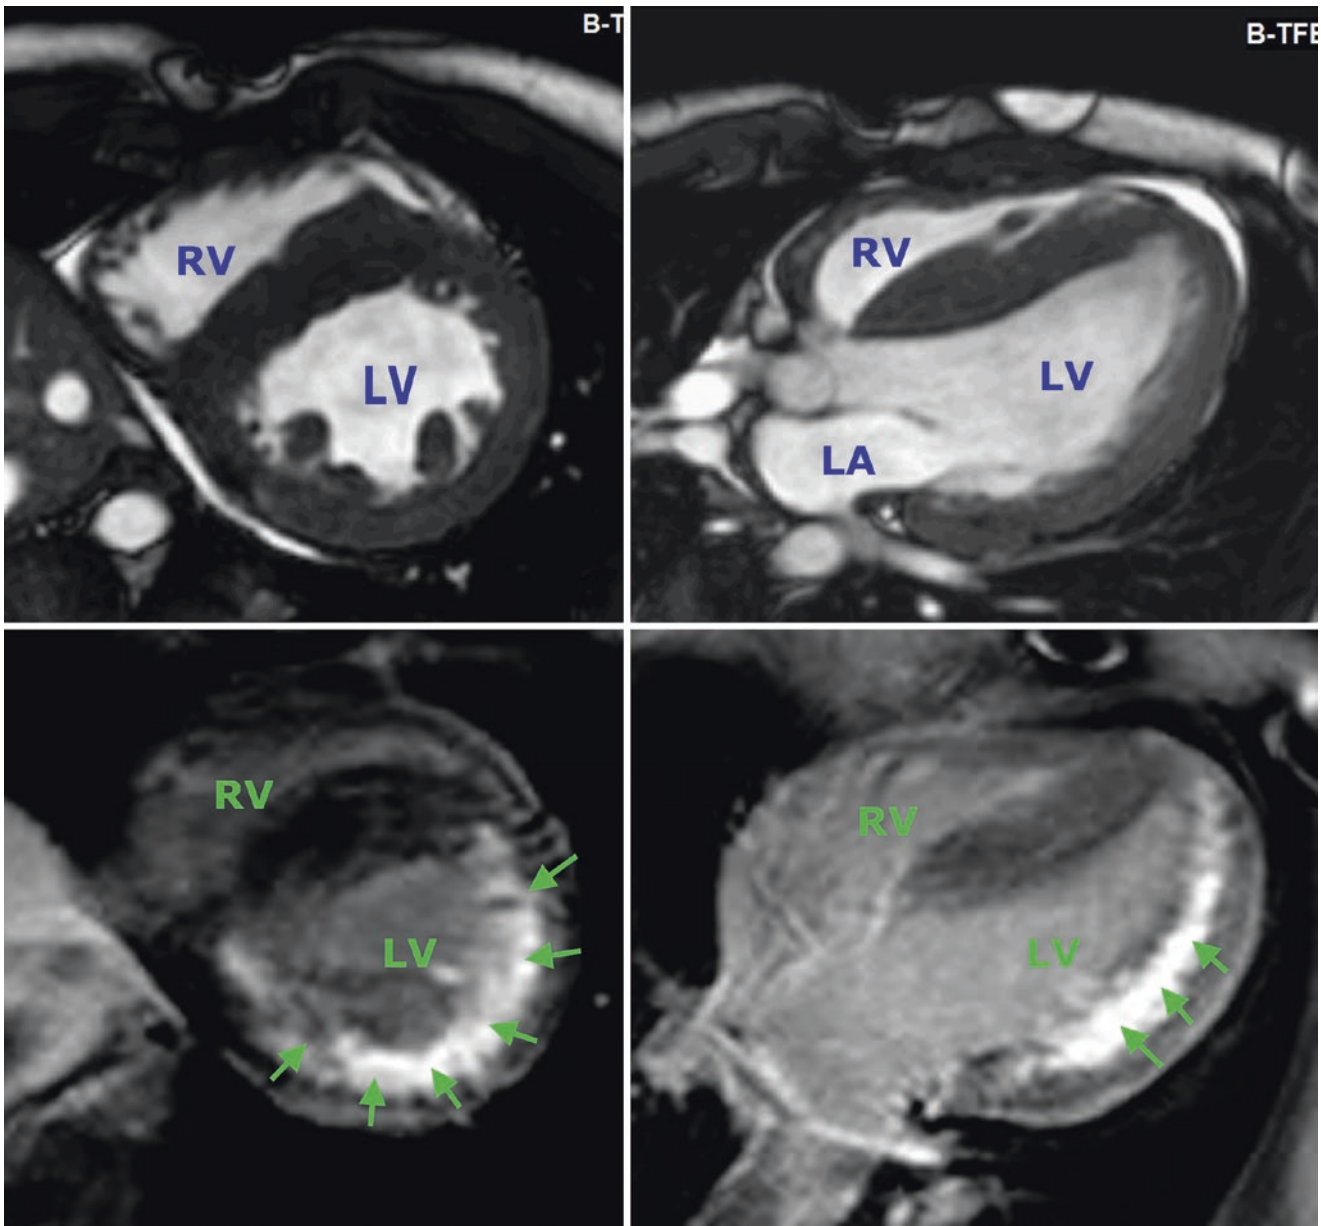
Cardiac MRI from a 17-year-old male patient affected by Danon disease showing diffuse homogenous left ventricular hypertrophy (upper panels). Extensive fibrosis is demonstrated by late gadolinium enhancement (lower panels)
